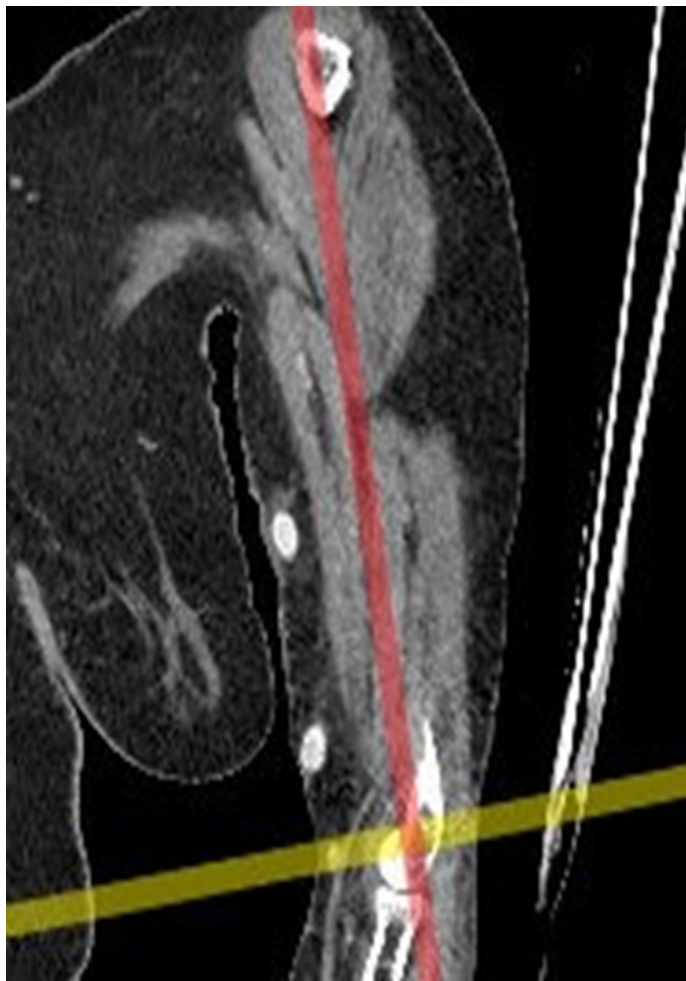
Representative CT image demonstrating alignment of the capitulum humeri to the orthogonal plane [intersection point of the sagittal axis (red line) and the transverse axis (yellow line) on the sagittal plane]
